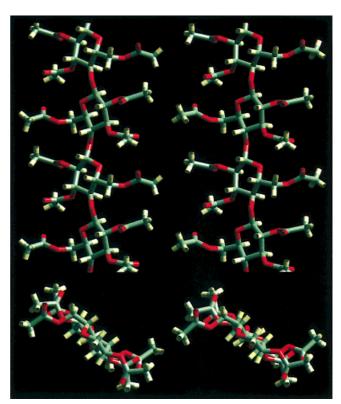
Calculated structure of the laminate CTA-I matrix on the basis of an X-ray structure analysis. The coordinates of each atom are taken from ref. [72c]. View along the chain axis (top) and perpendicular to the chain axis (bottom).
